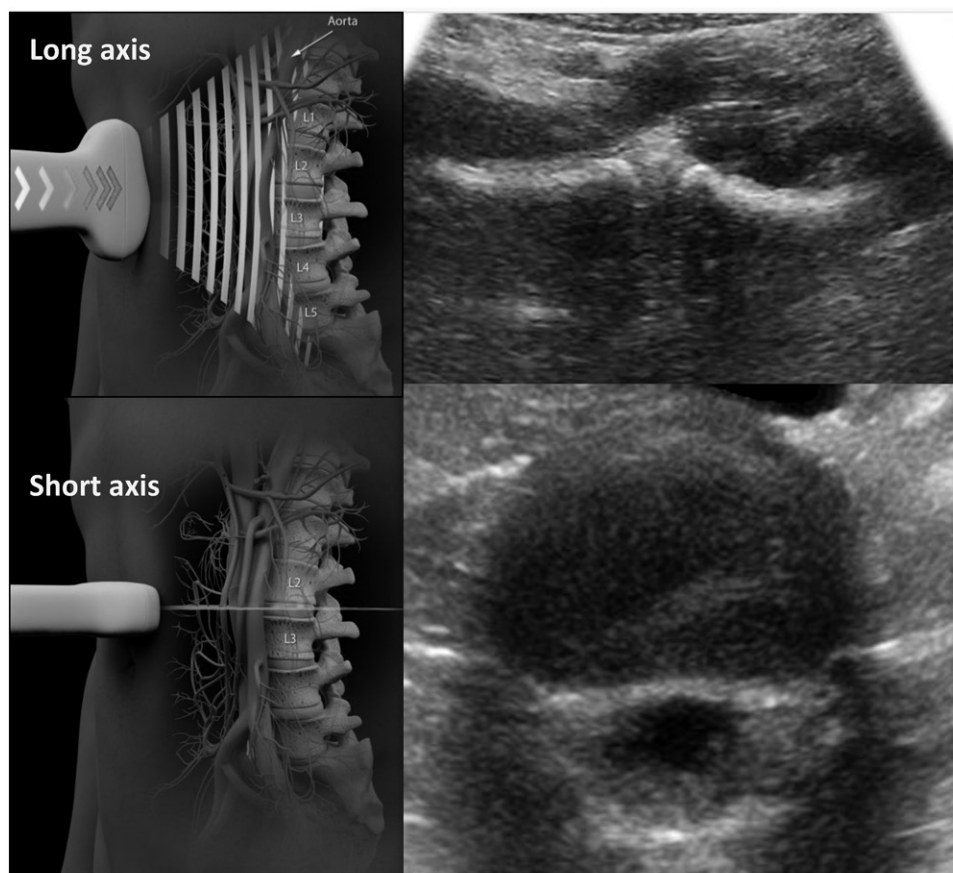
Computer based software provided just in time education to simplify spinal ultrasound for the crewmembers. This demonstrates probe positioning for visualizing an intervertebral disc space with two orthogonal imaging planes from the transabdominal approach with the aorta or inferior vena cava providing acoustic windows to enhance image quality when possible. In this example, representative images of the probe application Lumbar 2–Lumbar 3 intervertebral disc space in the long and short axes are provided.
